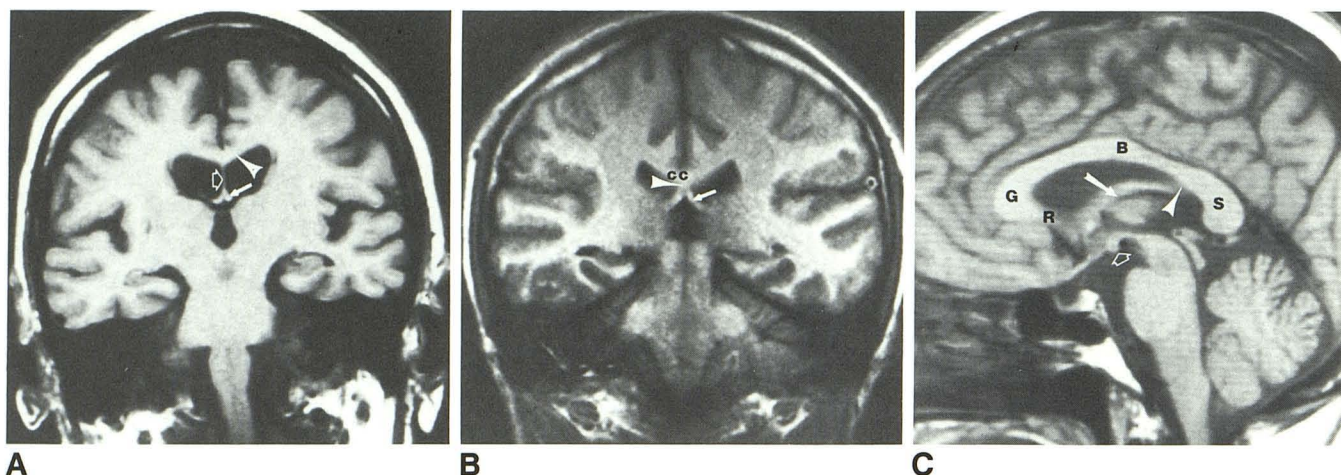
Normal coronal (A and B) and sagittal (C) T1-weighted MR images.
